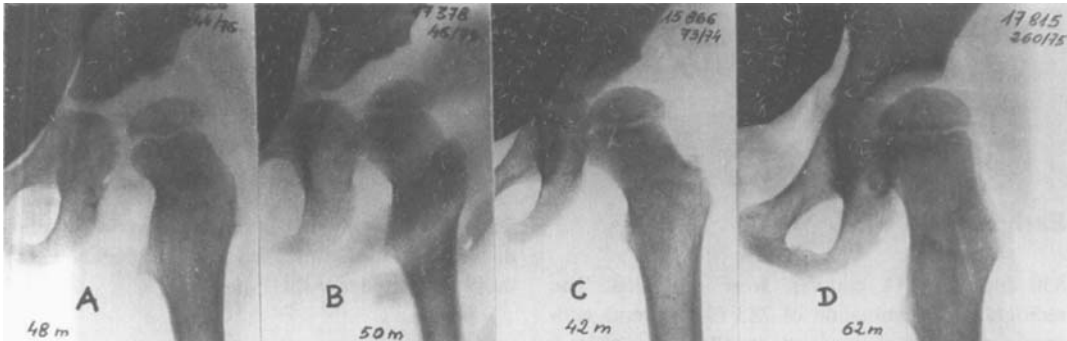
Preoperative radiographic appearances and subsequent surgical procedures in residual dysplasia. A arthrotomy, transiliac and subtrochanteric osteotomy. B transiliac and subtrochanteric osteotomy. C transiliac osteotomy only. D subtrochanteric osteotomy only.
